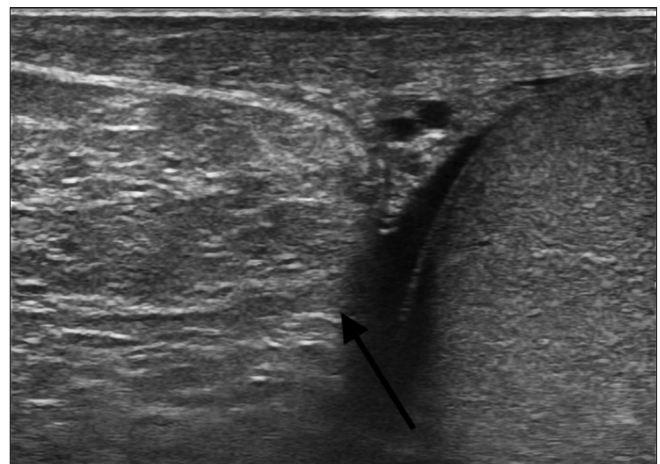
Greyscale Ultrasound image of left inguinoscrotal region
